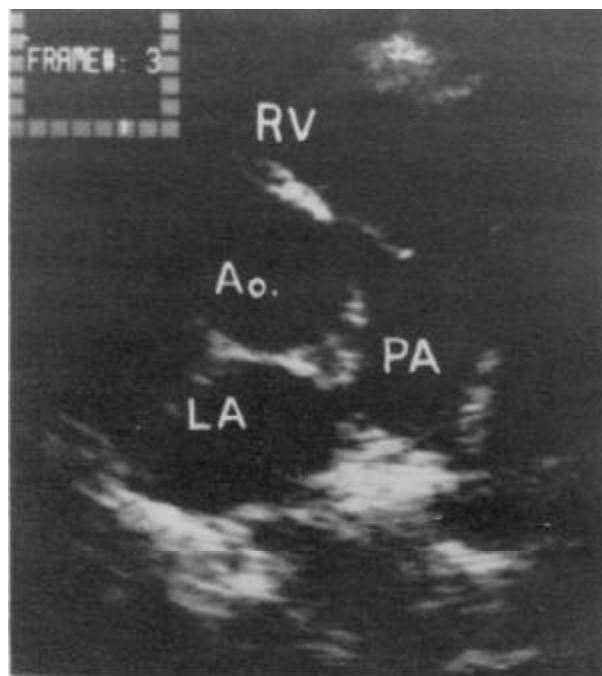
Conventional parasternal short axis image. Systolic doming of the pulmonary valve is apparent. RV | Right ventricle; PA | Pulmonary artery. Other abbreviations as before.
